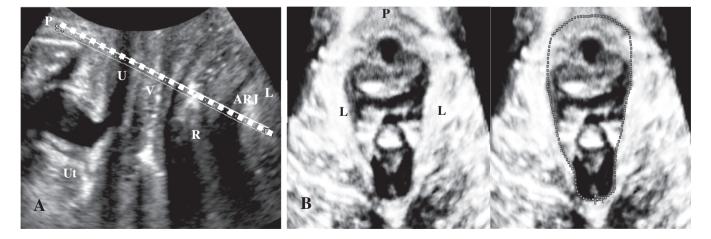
Ultrasonography images. (A) Determination of the plane of minimum levator hiatal dimension in a midsagittal plane. Dotted line shows the location of the plane of minimum hiatal dimension that is identified as the minimal distance between the symphysis pubis (P) and the anorectal junction (ARJ). (B) Area measurement of the levator hiatus in the axial plane of the minimum dimension. P, symphysis pubis; U, urethra; V, vagina; Ut, uterus; R rectum; ARJ, anorectal junction; L, levator ani
